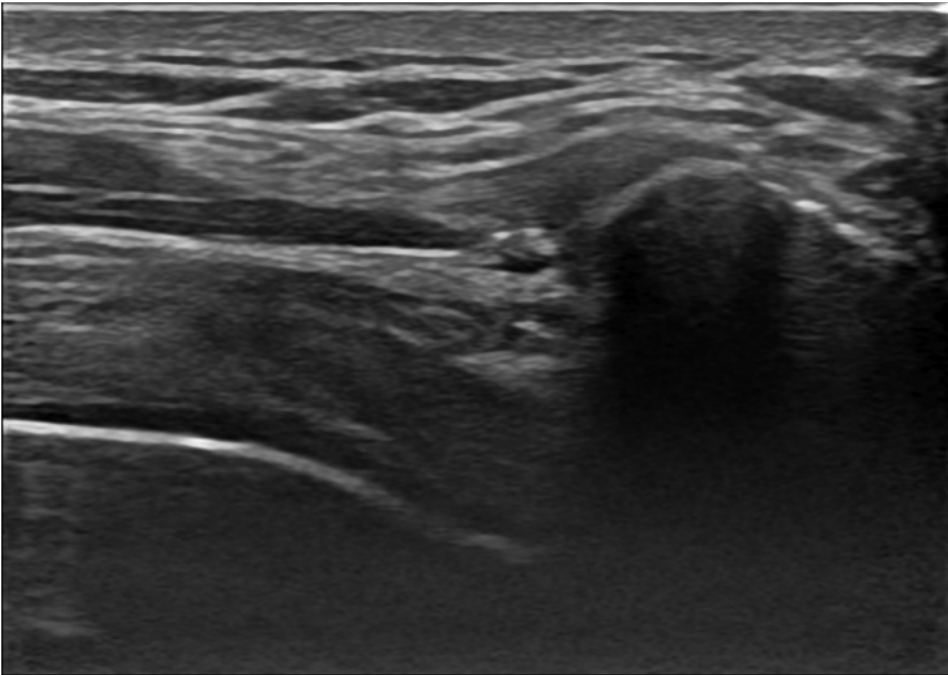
ULTRASONOGRAPHIC VISUALIZATION OF THE ACROMIO-HUMERAL DISTANCE
